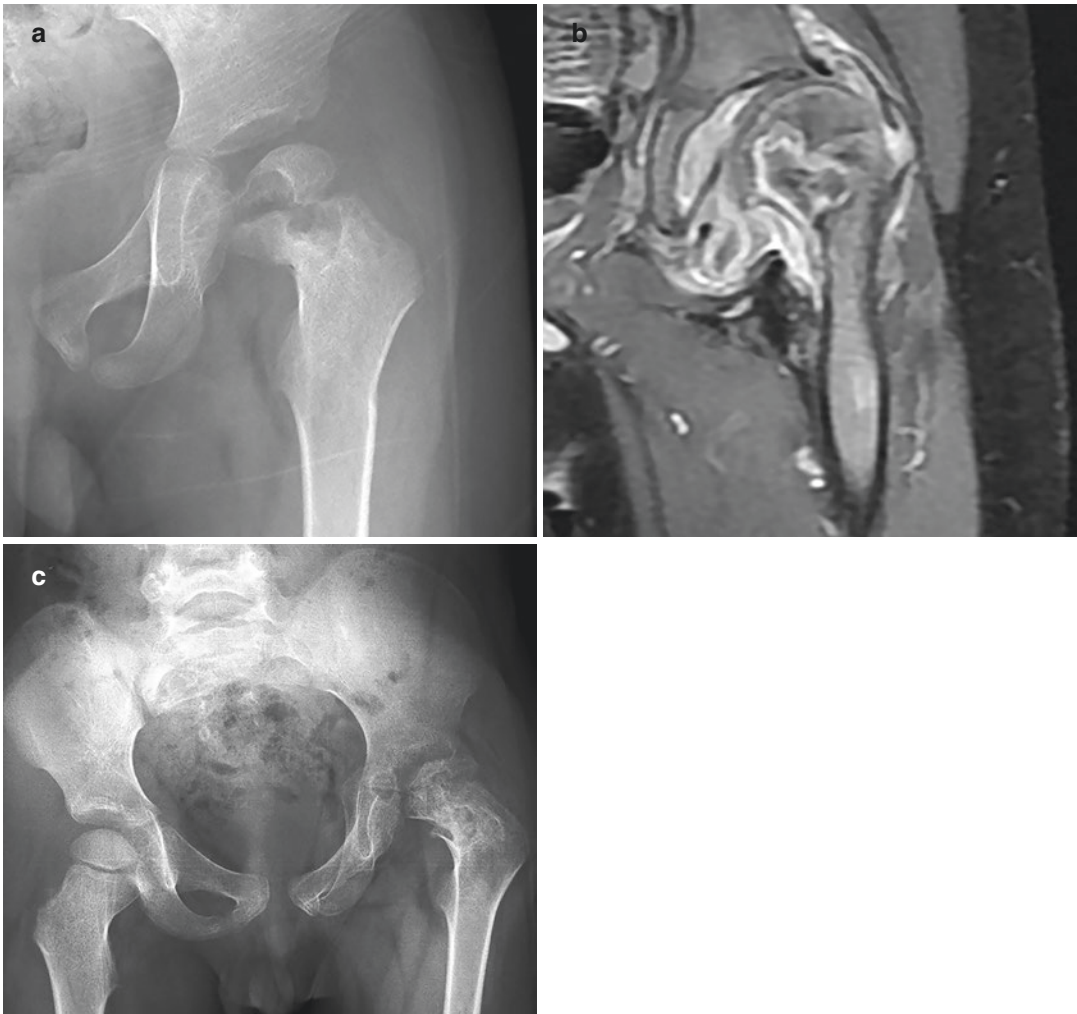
Tuberculous osteomyelitis with transphyseal spread and arthritis in a 4-year-old girl. (a) Frontal radiograph shows an osteolytic lesion in the metaphysis with extension to the proximal femoral epiphysis. (b) Coronal contrast-enhanced fat-suppressed T1-weighted MR image shows transphyseal extension of the intraosseous abscess and synovial enhancement indicating joint involvement.
